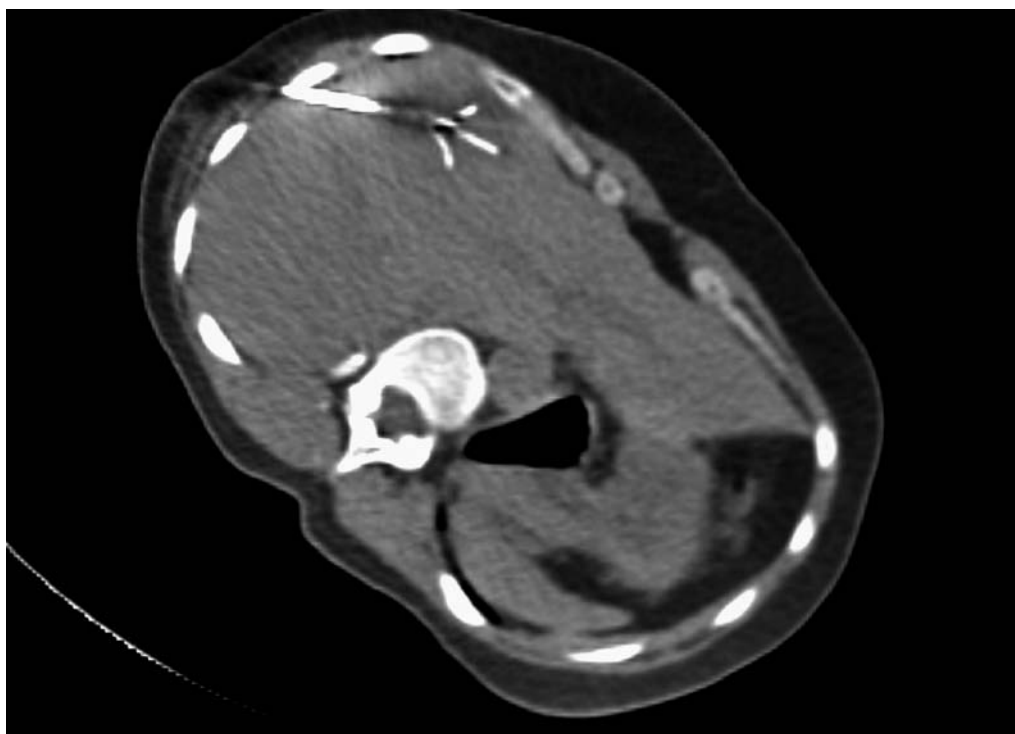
CT fluoroscopy during radiofrequency ablation of a liver tumor
